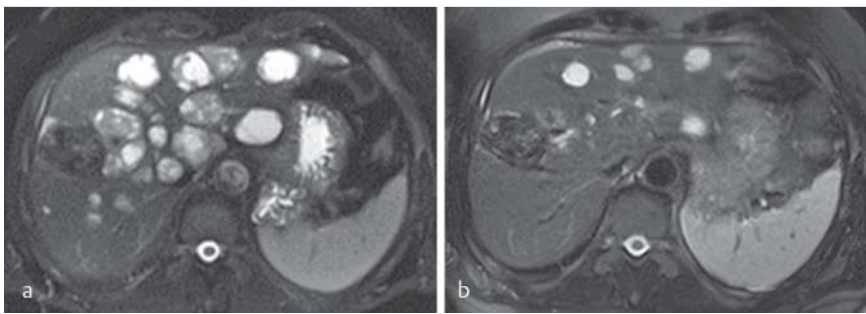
Magnetic resonance images (T2 haste) pre-treatment a and 8 weeks post-treatment b of a patient with metastatic ocular melanoma. The liver metastases showed a reduction in size of over 30% (partial response).
